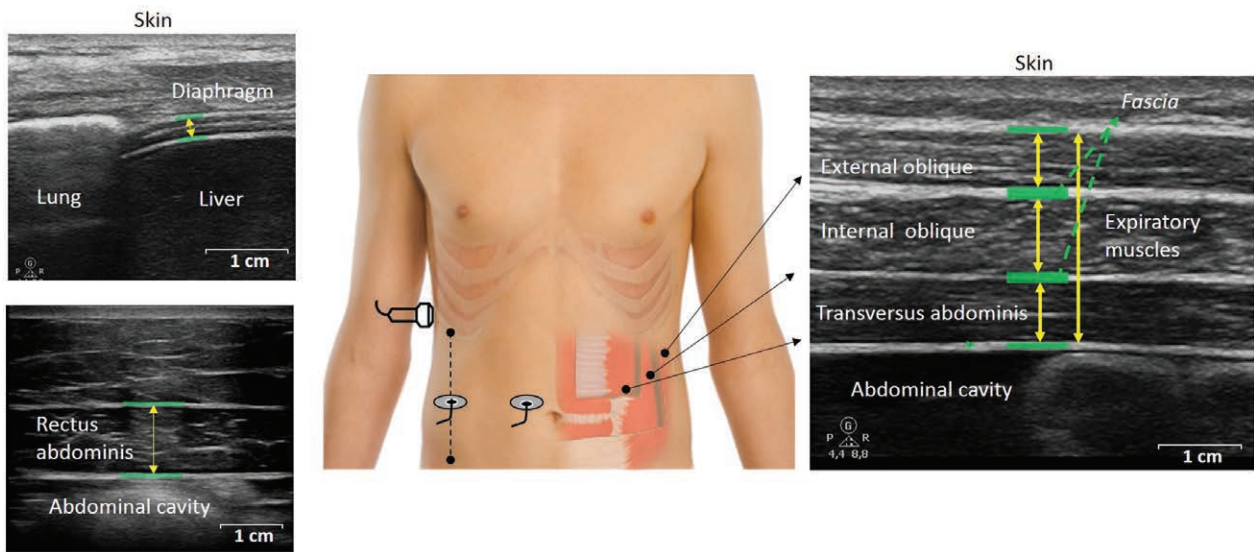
(Top left) Representative ultrasound image of the diaphragm. The muscle thickness was measured as the distance between the inner layers of the fasciae at end expiration. The probe was located at the zone of apposition between the midaxillary or anterior–axillary line in the 8th to 11th intercostal space. (Bottom left) Representative ultrasound image of the rectus abdominis muscle. The measurement of the muscle thickness was performed at end inspiration and was performed perpendicular to the inner layer of the muscle fascia. The probe was located at approximately 2 to 3 cm above the umbilicus and 2 to 3 cm lateral from the midline. (Right) Representative ultrasound image of the lateral abdominal expiratory muscles, showing three muscles from the top to bottom: external oblique, internal oblique, and transversus abdominis muscles. The measurements of the thickness of expiratory muscles and individual layers were performed at end inspiration and were performed perpendicular to the inner side of the muscle fascia (yellow arrow). The muscle fasciae are presented as green lines. The probe for the lateral abdominal muscles measurement was located approximately on the anterior axillary line, midway between the inferior border of the rib cage and the iliac crest.
